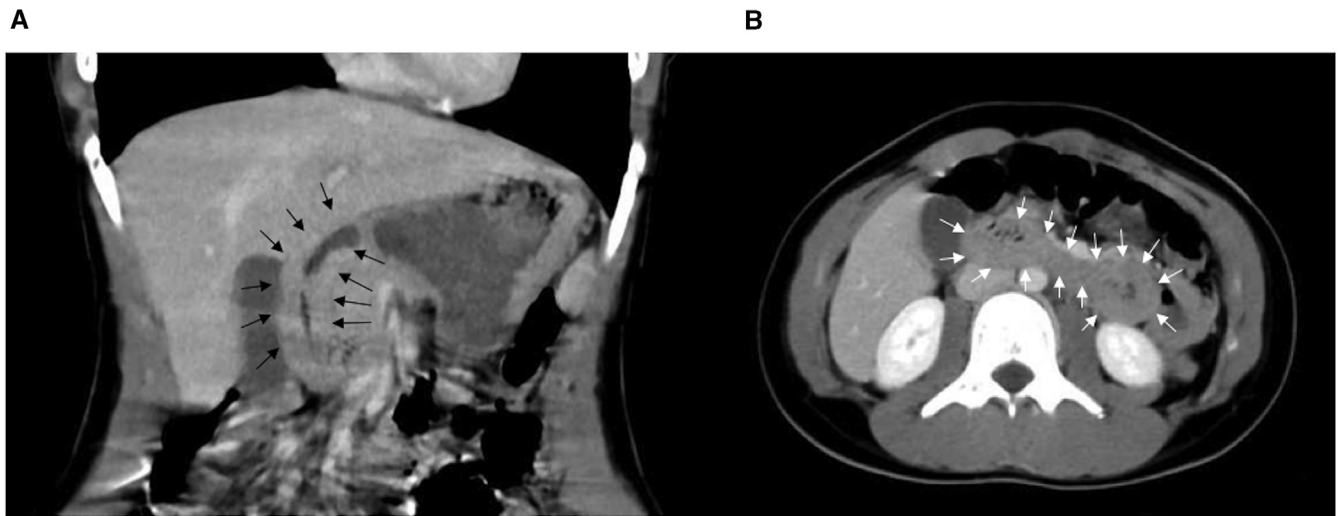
Arterial phase computed tomography. A, Nonthickening of the first to second segment of the duodenum. B, Nonthickening of the third to fourth segment of the duodenum.
